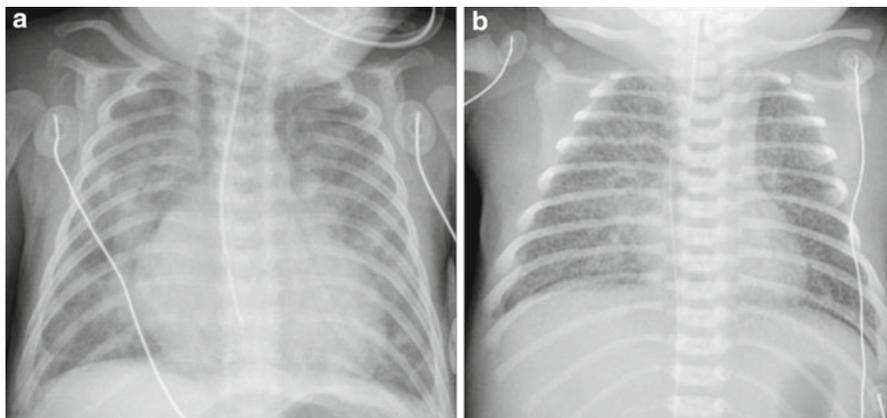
Increased vascular flow. (a) Neonate with ventricular septal defect. Chest radiograph shows cardiomegaly and increased vascular flow. Note that the tip of the nasogastric tube is malpositioned in the distal esophagus. (b) Chest radiograph in a neonate with total anomalous pulmonary venous return and interstitial edema. The heart is not significantly enlarged. Bilateral pulmonary vessels are ill defined representing venous congestion. Prominent and bilateral interstitial markings are seen suggesting edema. Associated small right pleural effusion is noted
